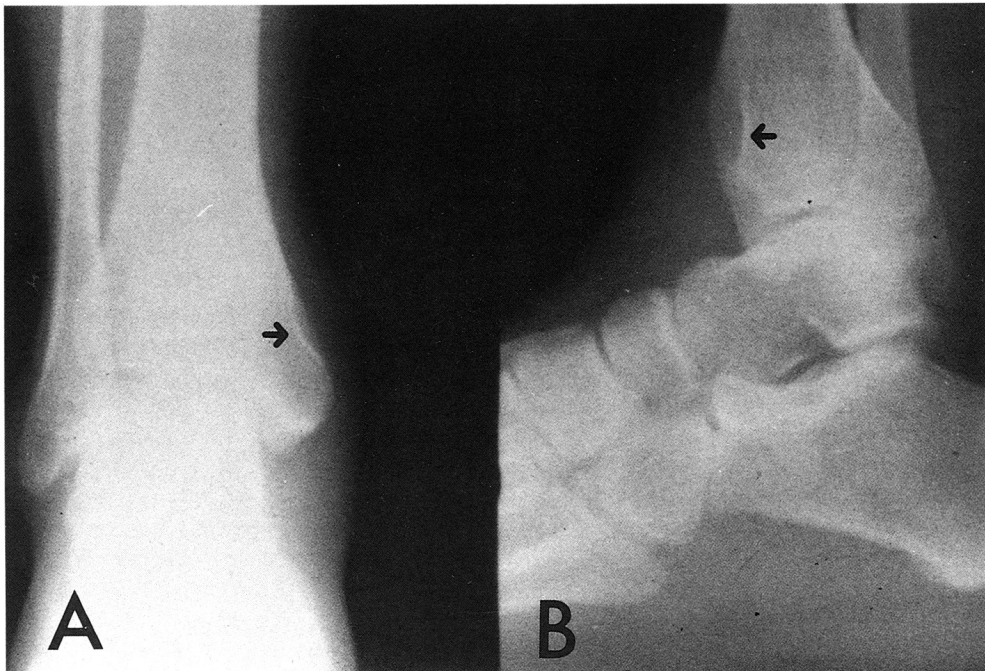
X-ray of the left tibia reveals a scalloping of the cortex (A, arrow) and sclerotic margin (B, arrow) on the medial malleolus.
